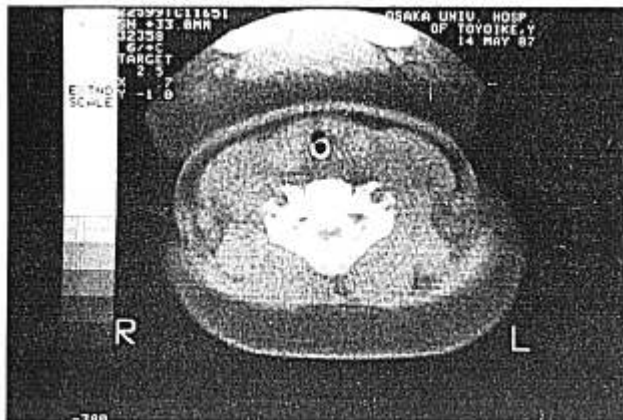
Transverse CT-scan of cervical myelography at C5 level in a different patient. No artifact was observed when our hand-made tube was used.
